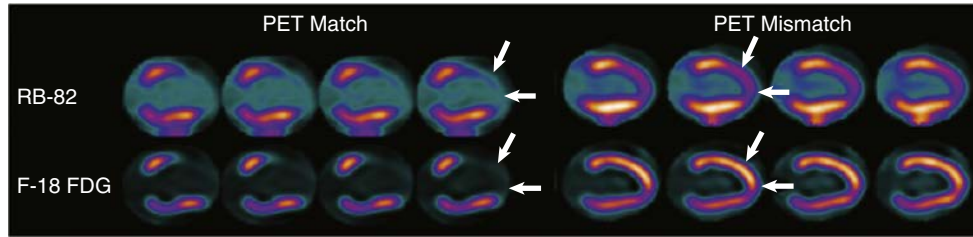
Examples of myocardial viability patterns assessed by integrating perfusion and metabolic imaging with positron emission tomography (PET) imaging. *Left*, Concordant reduction in perfusion (RB-82) and glucose uptake as labeled with ^{18}F -fluorodeoxyglucose (FDG) (arrows) throughout the anterior wall and apex, consistent with nonviable myocardium from previous infarction. *Right*, Increase in FDG uptake relative to perfusion in the anterior wall and apex, consistent with viable but hibernating myocardium. (From Di Carli MF, Hachamovitch R: New technology for noninvasive evaluation of coronary artery disease. *Circulation* 115:1464-1480, 2007.)
